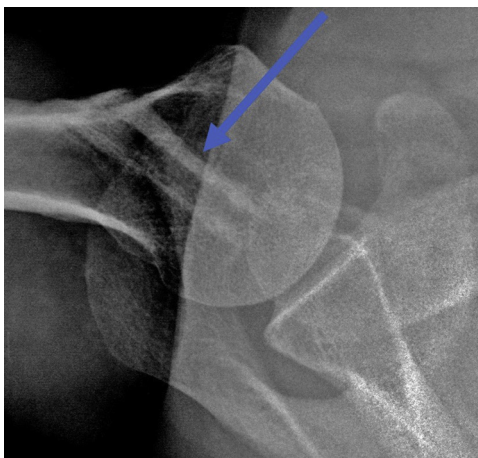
Postoperative Grashey radiograph of the right shoulder showing an incorporated fibular strut allograft at approximately 1.5 years (blue arrow).
